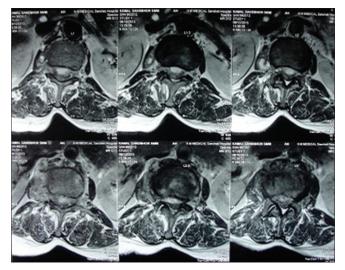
MRI of the spine showing L34 paravertebral collections.
